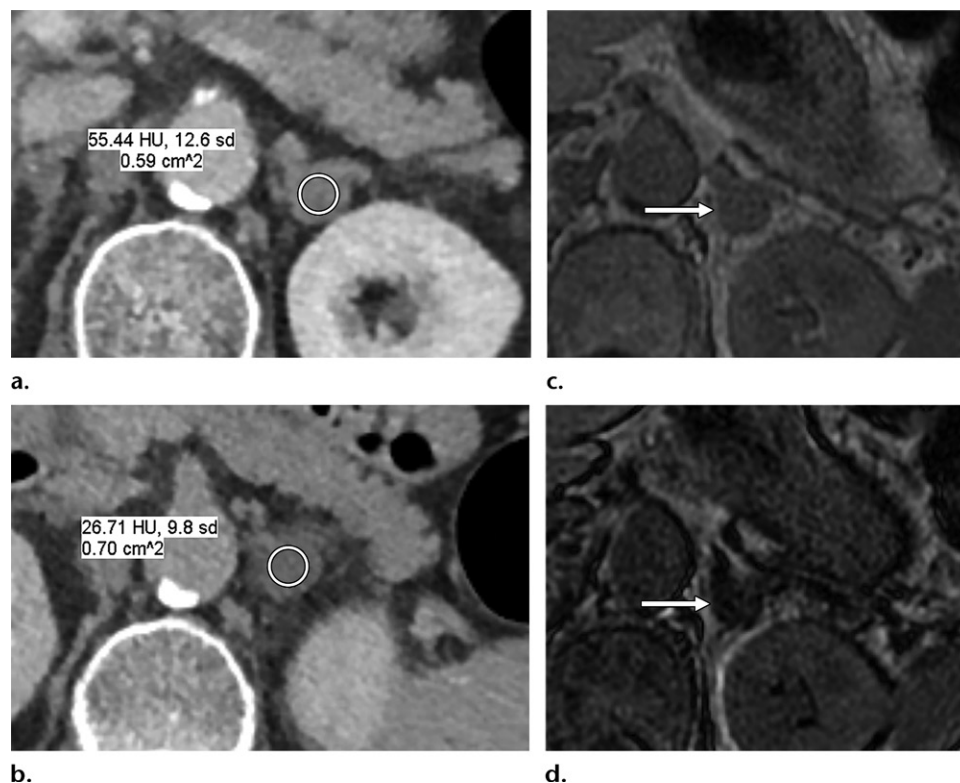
Assessment of washout at nondedicated imaging. (a, b) Axial contrast-enhanced CT colonography images obtained in the portal venous phase with the patient in the supine position (a) and at 3 minutes postcontrast with the patient in the prone position (b) show an incidental left adrenal nodule, which was considered indeterminate. (c, d) Axial in-phase (c) and out-of-phase (d) chemical shift MR images show signal loss within the lesion, consistent with a lipid-rich adenoma (arrow). This diagnosis could have been made at initial imaging without proceeding to further imaging. Relative washout could have been calculated at the nondedicated examination because, in addition to the portal venous phase examination, a delayed postcontrast acquisition had been obtained within 15 minutes. In this case, the relative washout value was 52%. If the washout value did not satisfy the established washout parameters, an adenoma could not have been excluded without further dedicated adrenal imaging.
